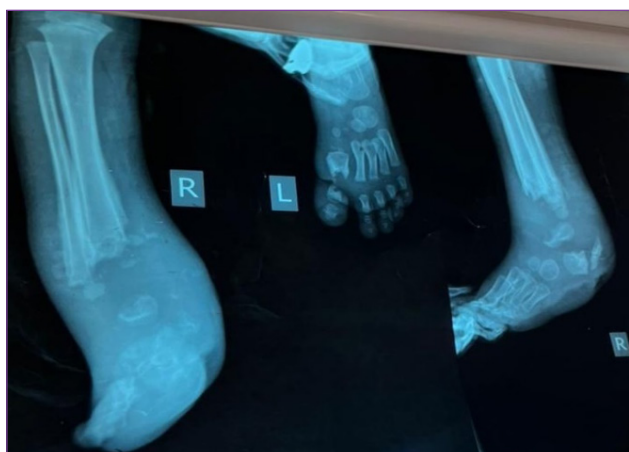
X-Ray of right and left ankle joints: shows nearly destroyed joints by inhomogeneous bone sclerosis with the formation of sequestra (osteomyelitis).
